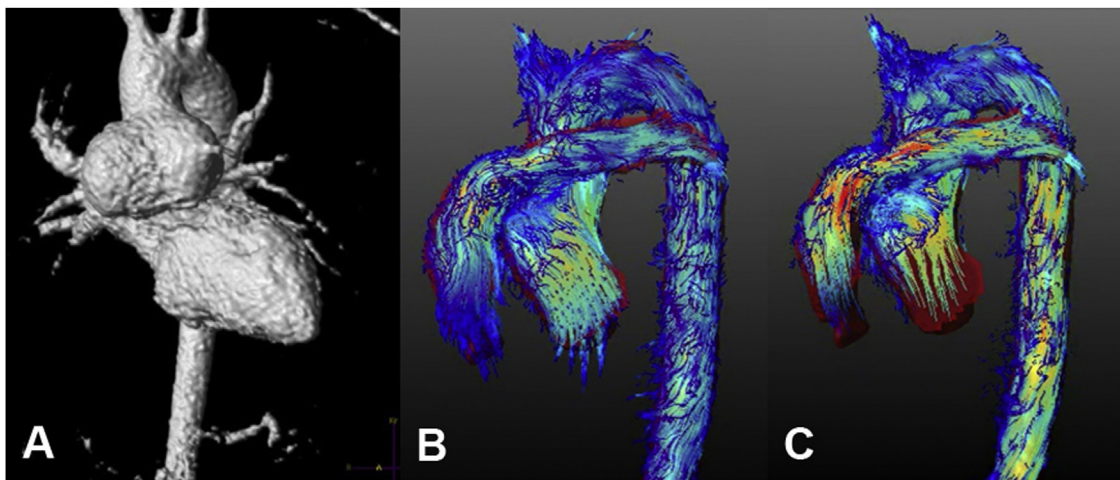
Transposition of the great arteries after arterial switch operation. (A) Anterior–posterior view: long-term follow-up with MRI shows a significantly dilated aortic sinus in contrast-enhanced magnetic resonance-angiography (MRA); (B) lateral view: vortex formation in the distal pulmonary arteries (arrow) in early systole; (C) lateral view: vortex formation in the aortic sinus in late systole.
